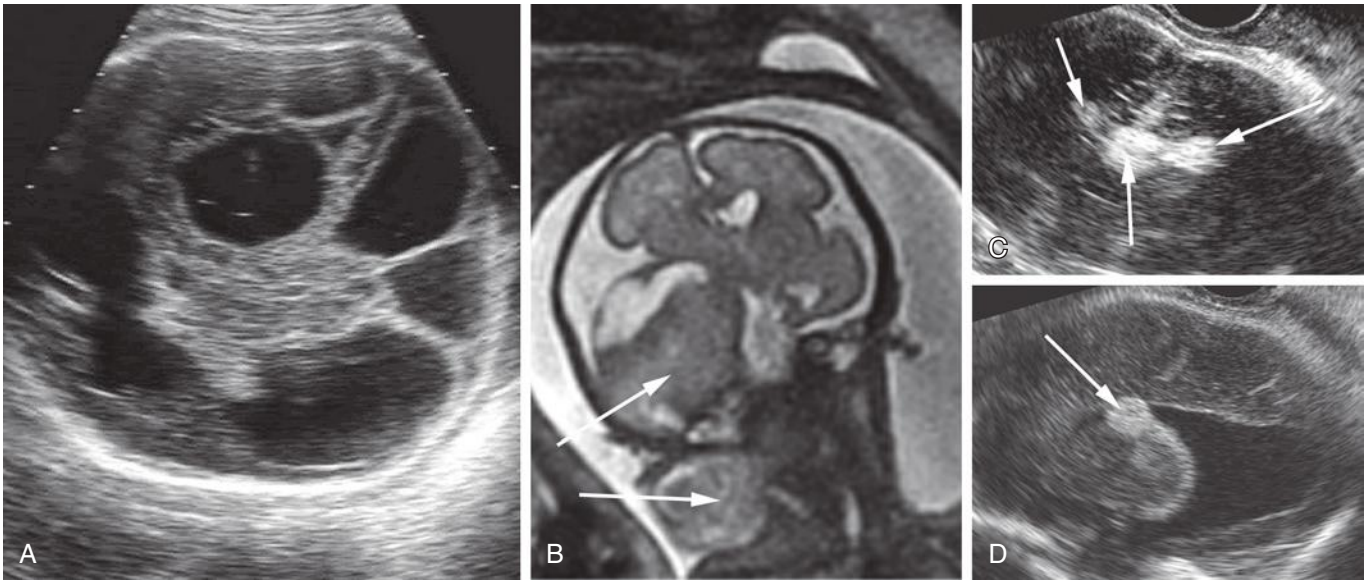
Fetal intracranial tumors: intracranial teratoma as visualized by ultrasound (A) and magnetic resonance imaging (B) (*arrows*). Multiple lipomas appear as echogenic round masses (*arrows*) in a fetus with associated agenesis of the corpus callosum (C and D).
